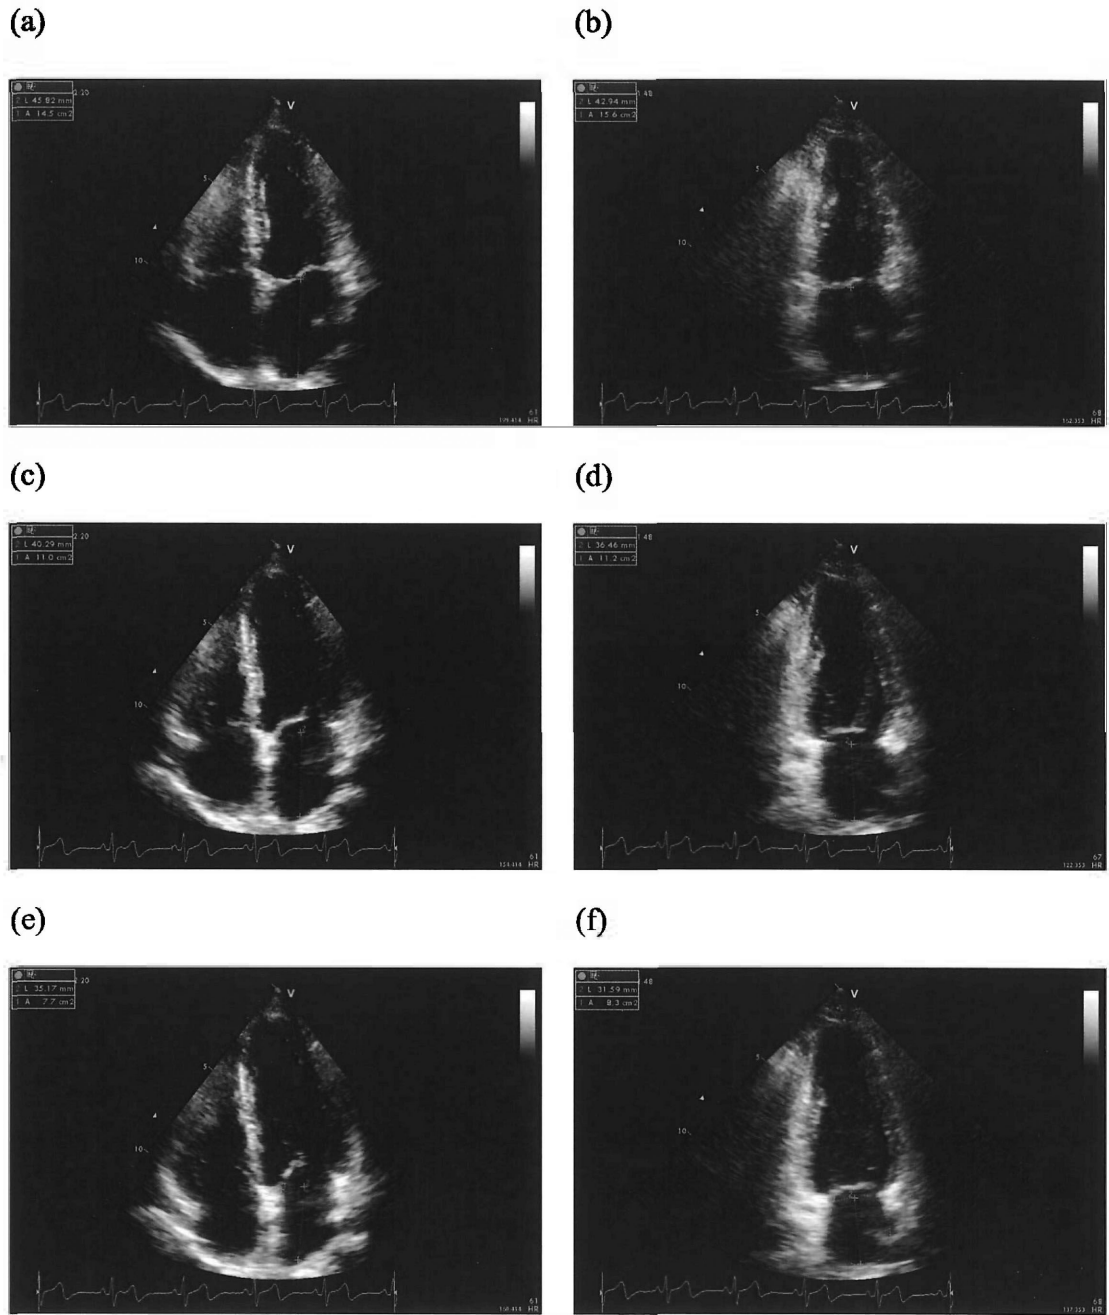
Example of measurement LA volume using biplane area-length method. The areas are obtained from apical 4-chamber (A4c) and apical 2-chamber (A2c) and the length (L) is measured from back wall to line across hinge points of mitral valve from either four- or two-chamber view. The formula is LA volume = $\frac{8}{3\pi} [(A4c) (A2c)/L]$. The maximal LA volume (a, b), pre-atrial contraction volume (c, d) and minimal volume (e, f) are calculated separately using apical four- and two-chamber views by area-length method.
